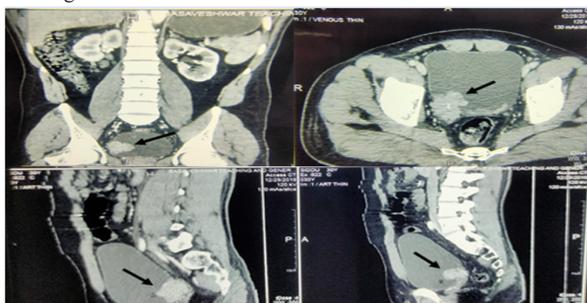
= CT scan showing growth in right lateral wall of urinary bladder
